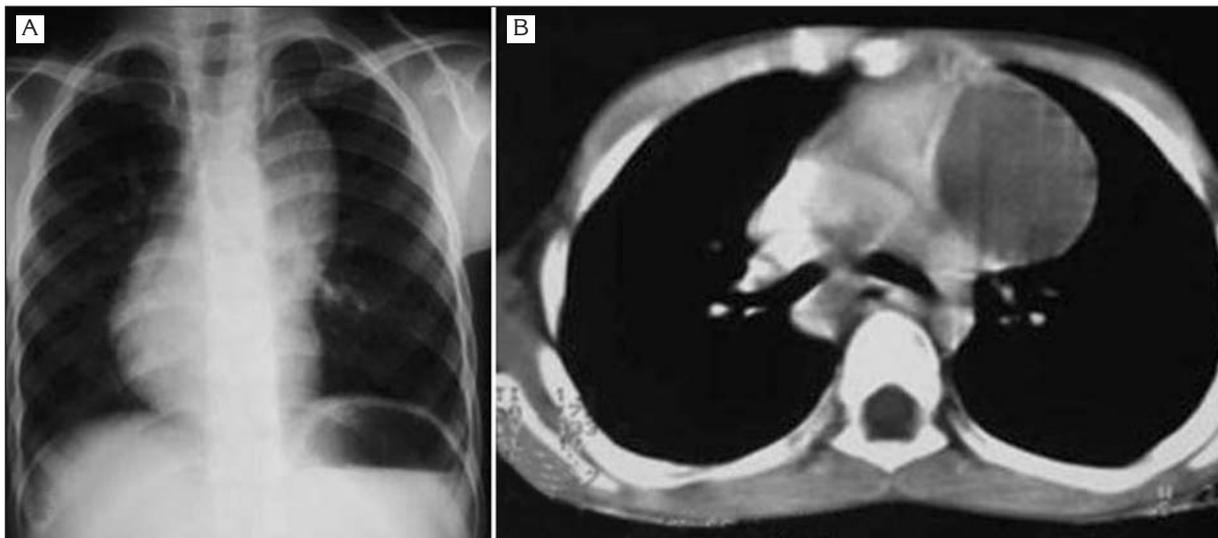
A: The anterior mediastinal mass displacing the mediastinum to the right on frontal chest X-ray of case 1. B: CT appearance of mass in case 1.
